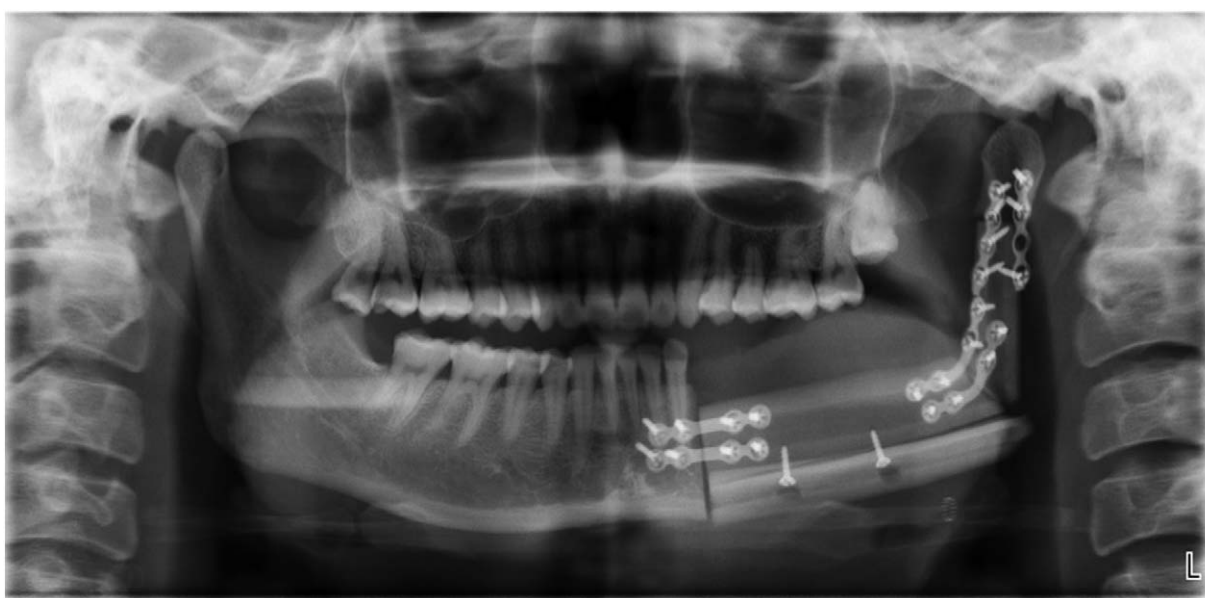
Postoperative panoramic radiography revealing the height of the mandible and the symmetry of the mandible.
